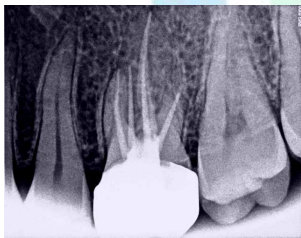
Radiograph after 6 months
